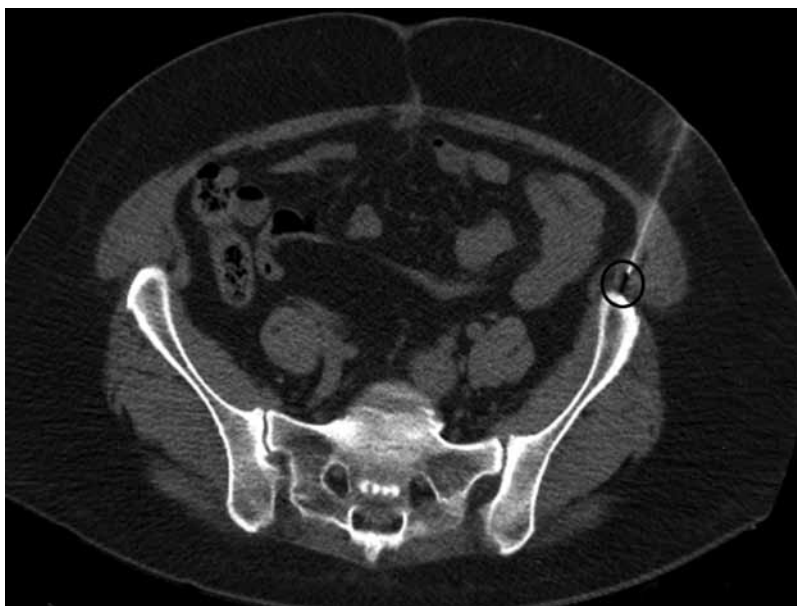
CT slice showing needle tip artifact (black circle) at defined target.
